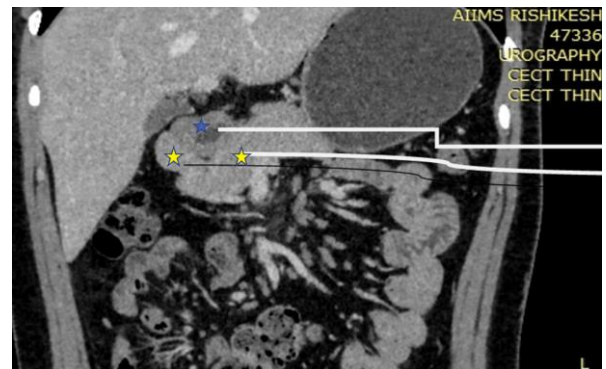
32 years old male. Coronal section of abdomen on contrast-enhanced computed tomography (CECT), showing second part of duodenum (marked by blue star), being incompletely encircled by pancreatic tissue (marked by yellow stars). A typical crocodile jaw configuration of the pancreatic tissue is seen around the second part of duodenum
